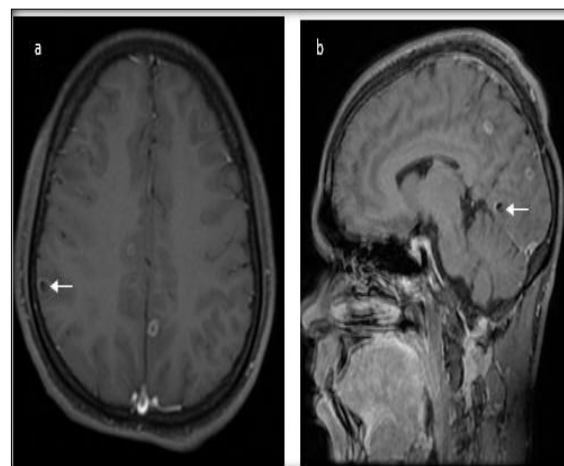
(a,b) T1-weighted postcontrast axial and sagittal images show ring enhancing, small well defined nodular lesions in bilateral parieto-occipital lobes at grey white matter interface. There is presence of eccentric T1 iso to hyper intense nodular component within representing scolex (white arrows). These features are suggestive of neurocysticercosis in vesicular stage. Origin: Department of Radiology, Jorhat Medical College and Hospital, Jorhat, Assam, India 2025.
